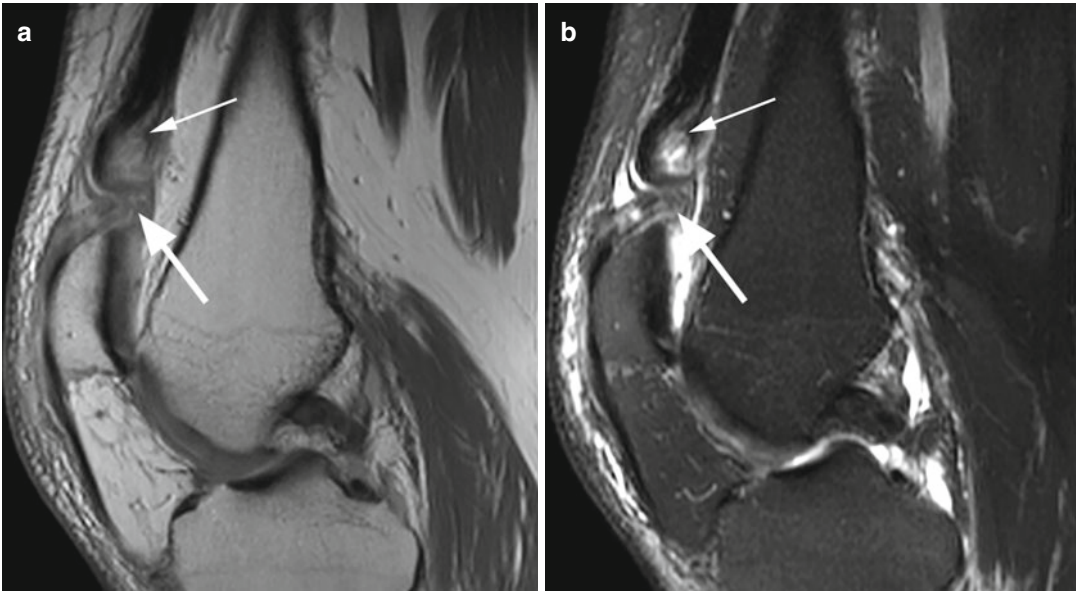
Complete quadriceps tendon tear in a 63 year old male. Sagittal proton-density (PD) image (a) and sagittal T2-weighted fat-suppressed image (b) show a complete tear of the quadriceps tendon (*large arrow*). Note the degenerative changes of the tendon (*small arrow*) which indicates a weakened tendon
